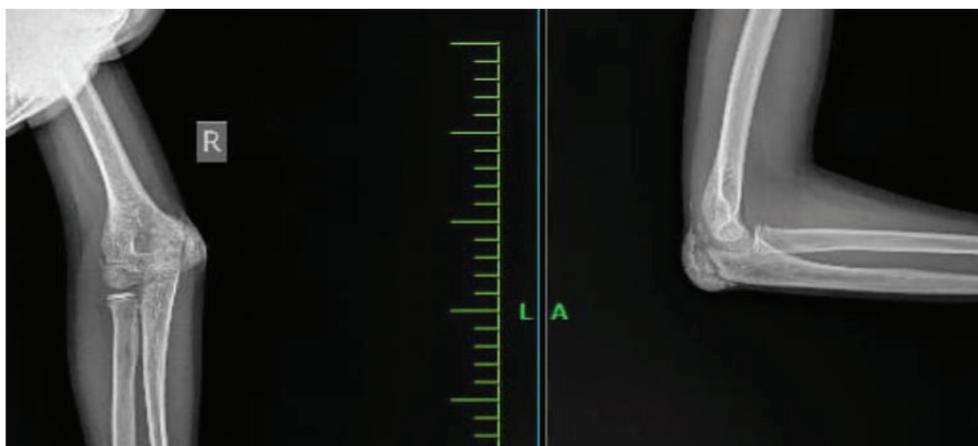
Preoperative radiograph of the right elbow showing small oval shape calcified mass over posteromedial region.
